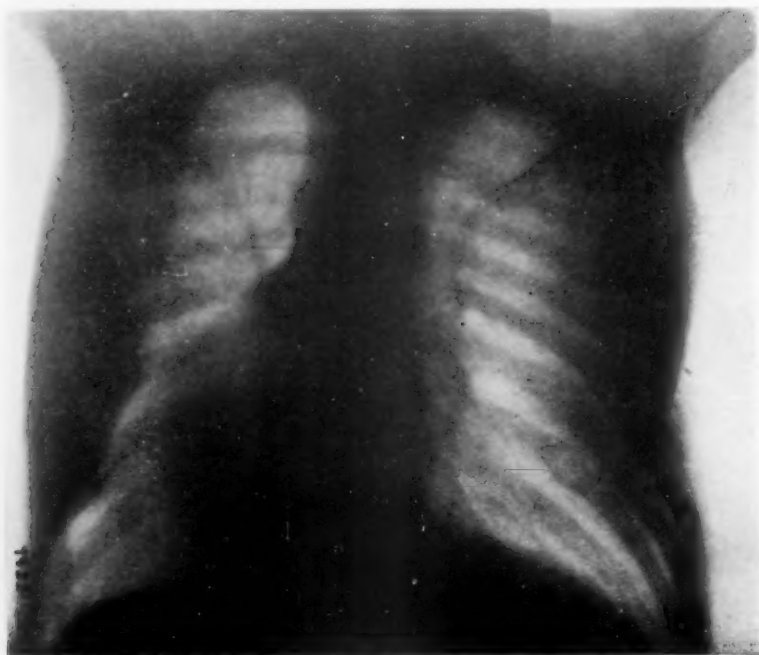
X-ray showing areas of osteolysis and fractures through pathologic processes in both ribs.
